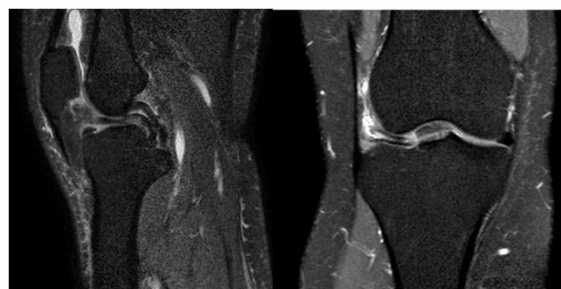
MRI Appearance of Meniscal Tear
